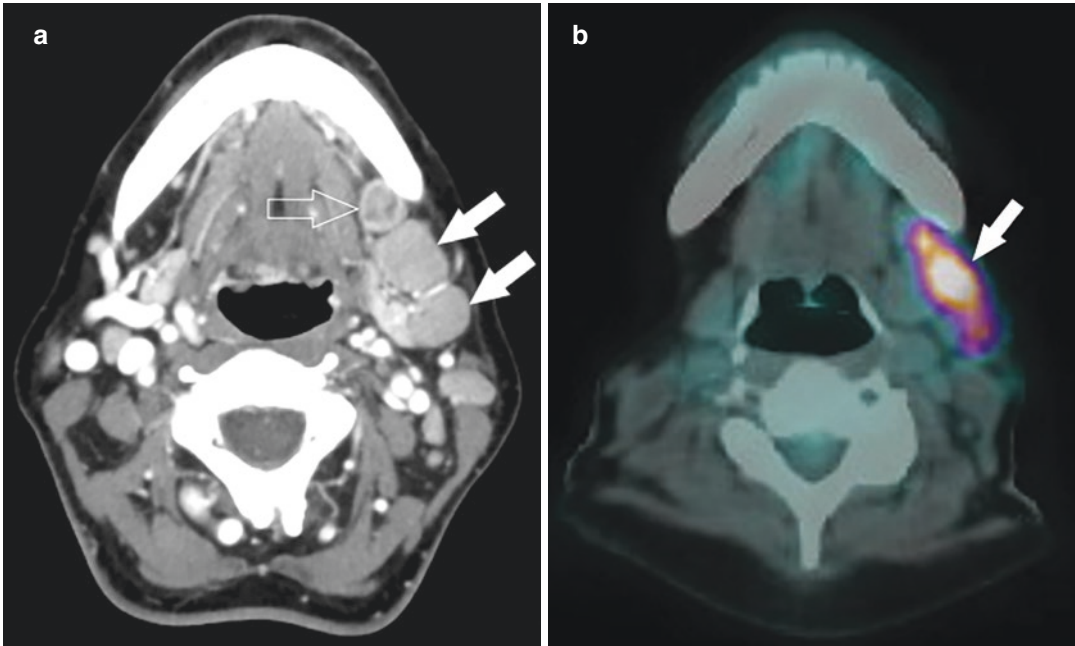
CT of tuberculous lymphadenitis (granulomatous stage). (a) Axial contrast-enhanced CT image shows lymphadenopathy at the left submandibular region, which has homogeneous enhancement (solid arrows). One of the nodes has rim enhancement with internal heterogeneous
